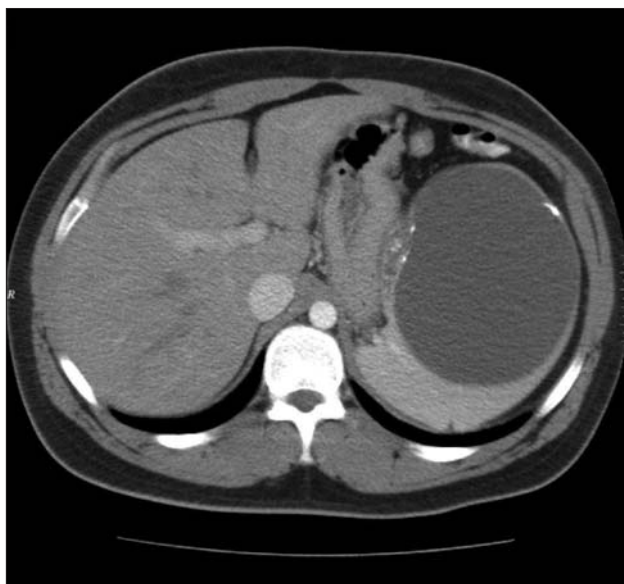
CT scan showing a large splenic cyst.
